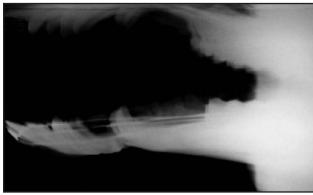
A latero-medial radiograph of mandible of camel showing immobilisation with interdental wiring. Note the slight overriding at fracture site.
